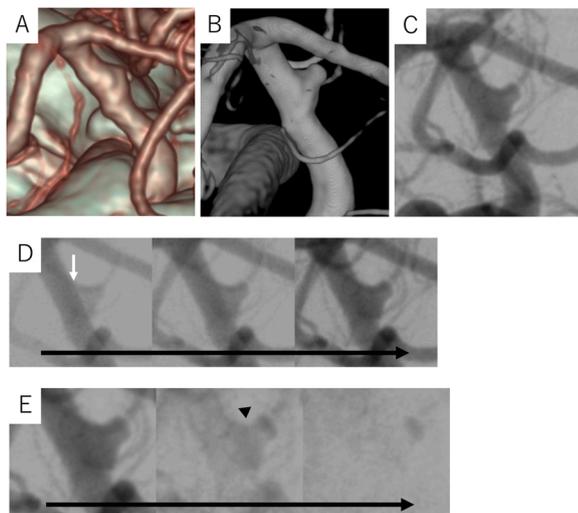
Findings for case 10 as a representative case. (A) 3D-CT angiography acquired at the first visit, demonstrating a fusiform dilatation of the ICA. (B,C) ICA angiogram at the time of treatment, 8 days after initial presentation, showing obvious morphological changes and a bleb-like formation at the fusiform dilatation. B was 3D-RA imaging and C was 2D-DSA imaging. (D) ICA angiogram showing delayed contrast medium inflow, with a clear contrast difference between the parent artery and the aneurysm (white arrow). (E) ICA angiogram showing delayed contrast medium outflow in the aneurysm, especially stagnation at the margin of the aneurysm wall (black arrow head). CT, computed tomography; ICA, internal carotid artery; RA, rotational angiography; DSA, digital subtraction angiography.
